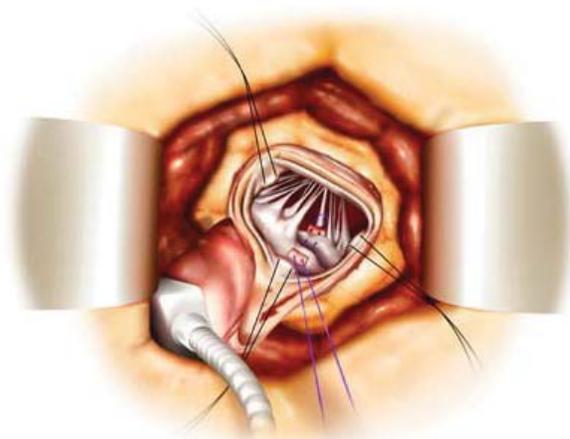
The surgeon's view of a transaortic edge-to-edge mitral repair during minimally invasive valve surgery utilizing a right parasternal approach.
